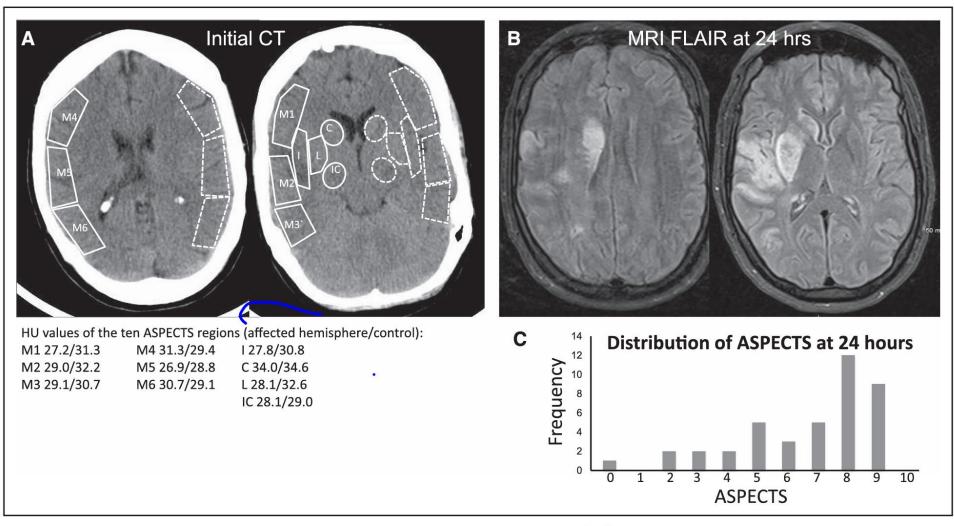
An example of initial computerized tomography head with Hounsfield unit (HU) values calculated between the 2 hemispheres. A, Ten ASPECTS (Alberta Stroke Program Early CT Score) regions are outlined manually. HU values representing each individual region are shown at the bottom. Solid lines label the affected hemisphere and dotted lines label contralateral (control) hemisphere. B, Follow-up magnetic resonance imaging fluid-attenuated inversion recovery repeated at 24 hours shows the extent of final stroke, ASPECTS=5. C, Distribution of ASPECTS at 24 hours. C indicates caudate; I, insular ribbon; IC, internal capsule; L, lentiform; and M1–6, middle cerebral artery cortical regions 1 to 6.
